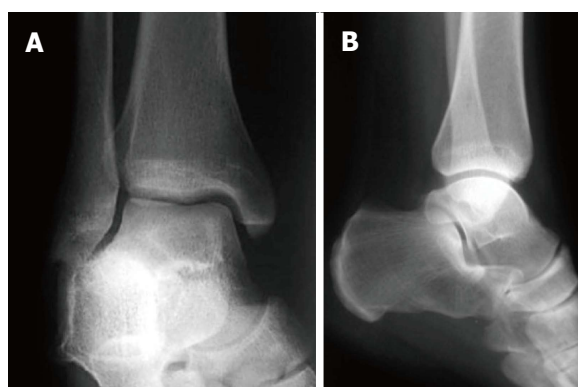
Examples for radiographs of the ankle: Mortise view (A) and lateral view (B).
